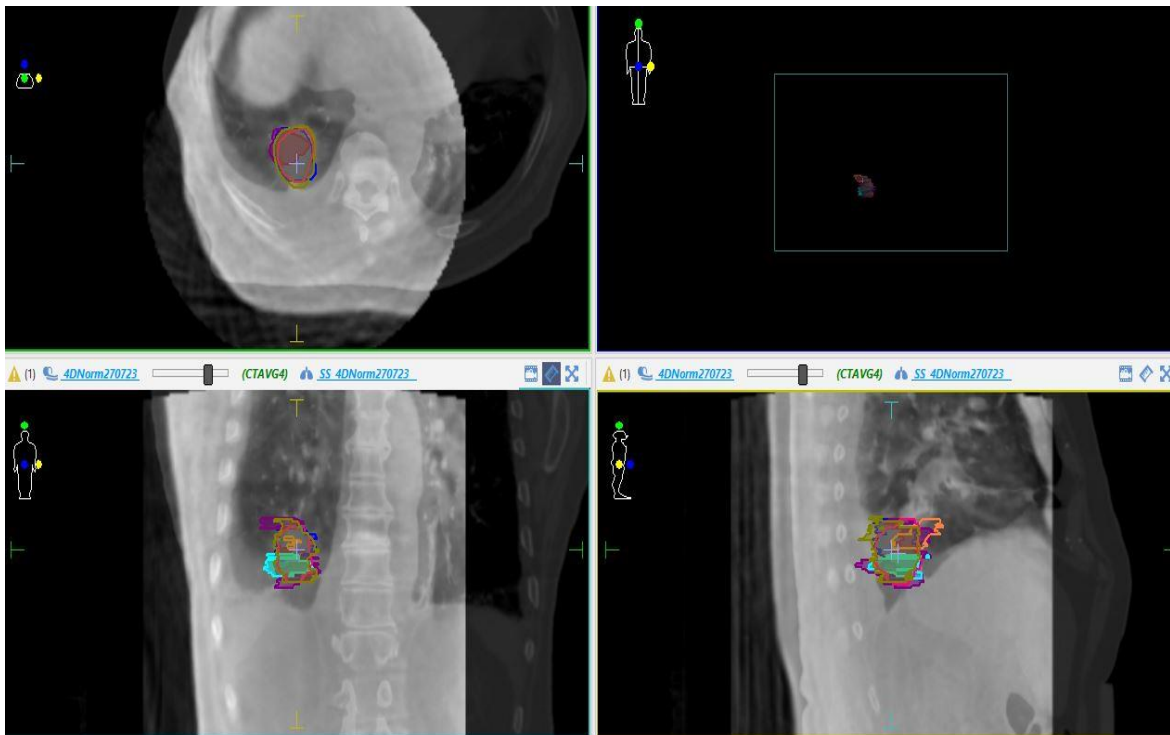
Place interest points for calculating the centroid positions in the 4DCBCT and ITV fusion images for a diaphragm lesion.
